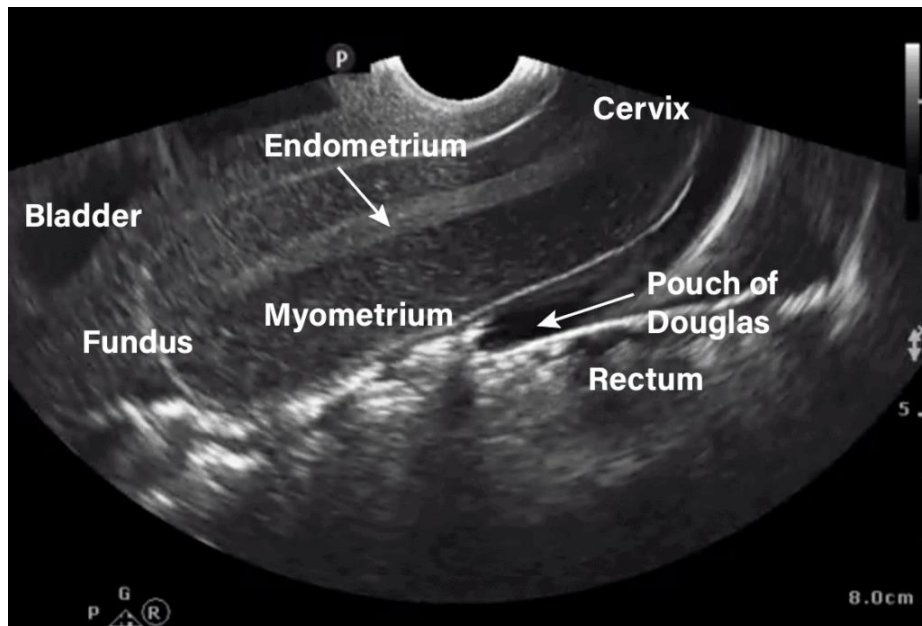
Sagittal transvaginal Ultrasound with free fluid in pouch of Douglas adopted form Ujaddughe O et al., 2024
